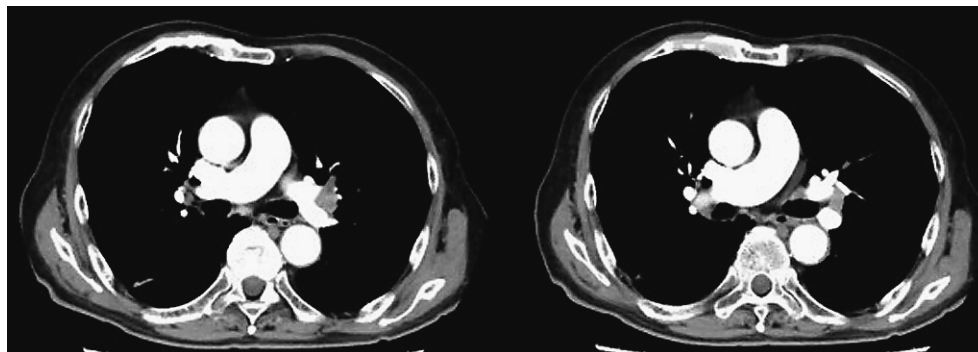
Chest computed tomography showing a hilar tumor obstructing the left upper division bronchus.
